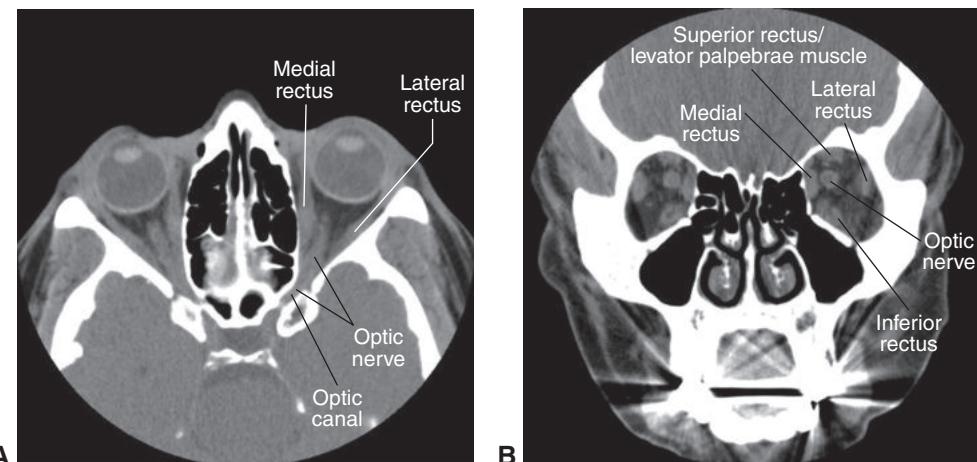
Computed tomography (CT) scans. A, Axial orbital view of a healthy subject. Note the orbital and intracanalicular portions of the optic nerve. B, Coronal orbital view of a healthy subject. (Courtesy of Rod Foroozan, MD.)
